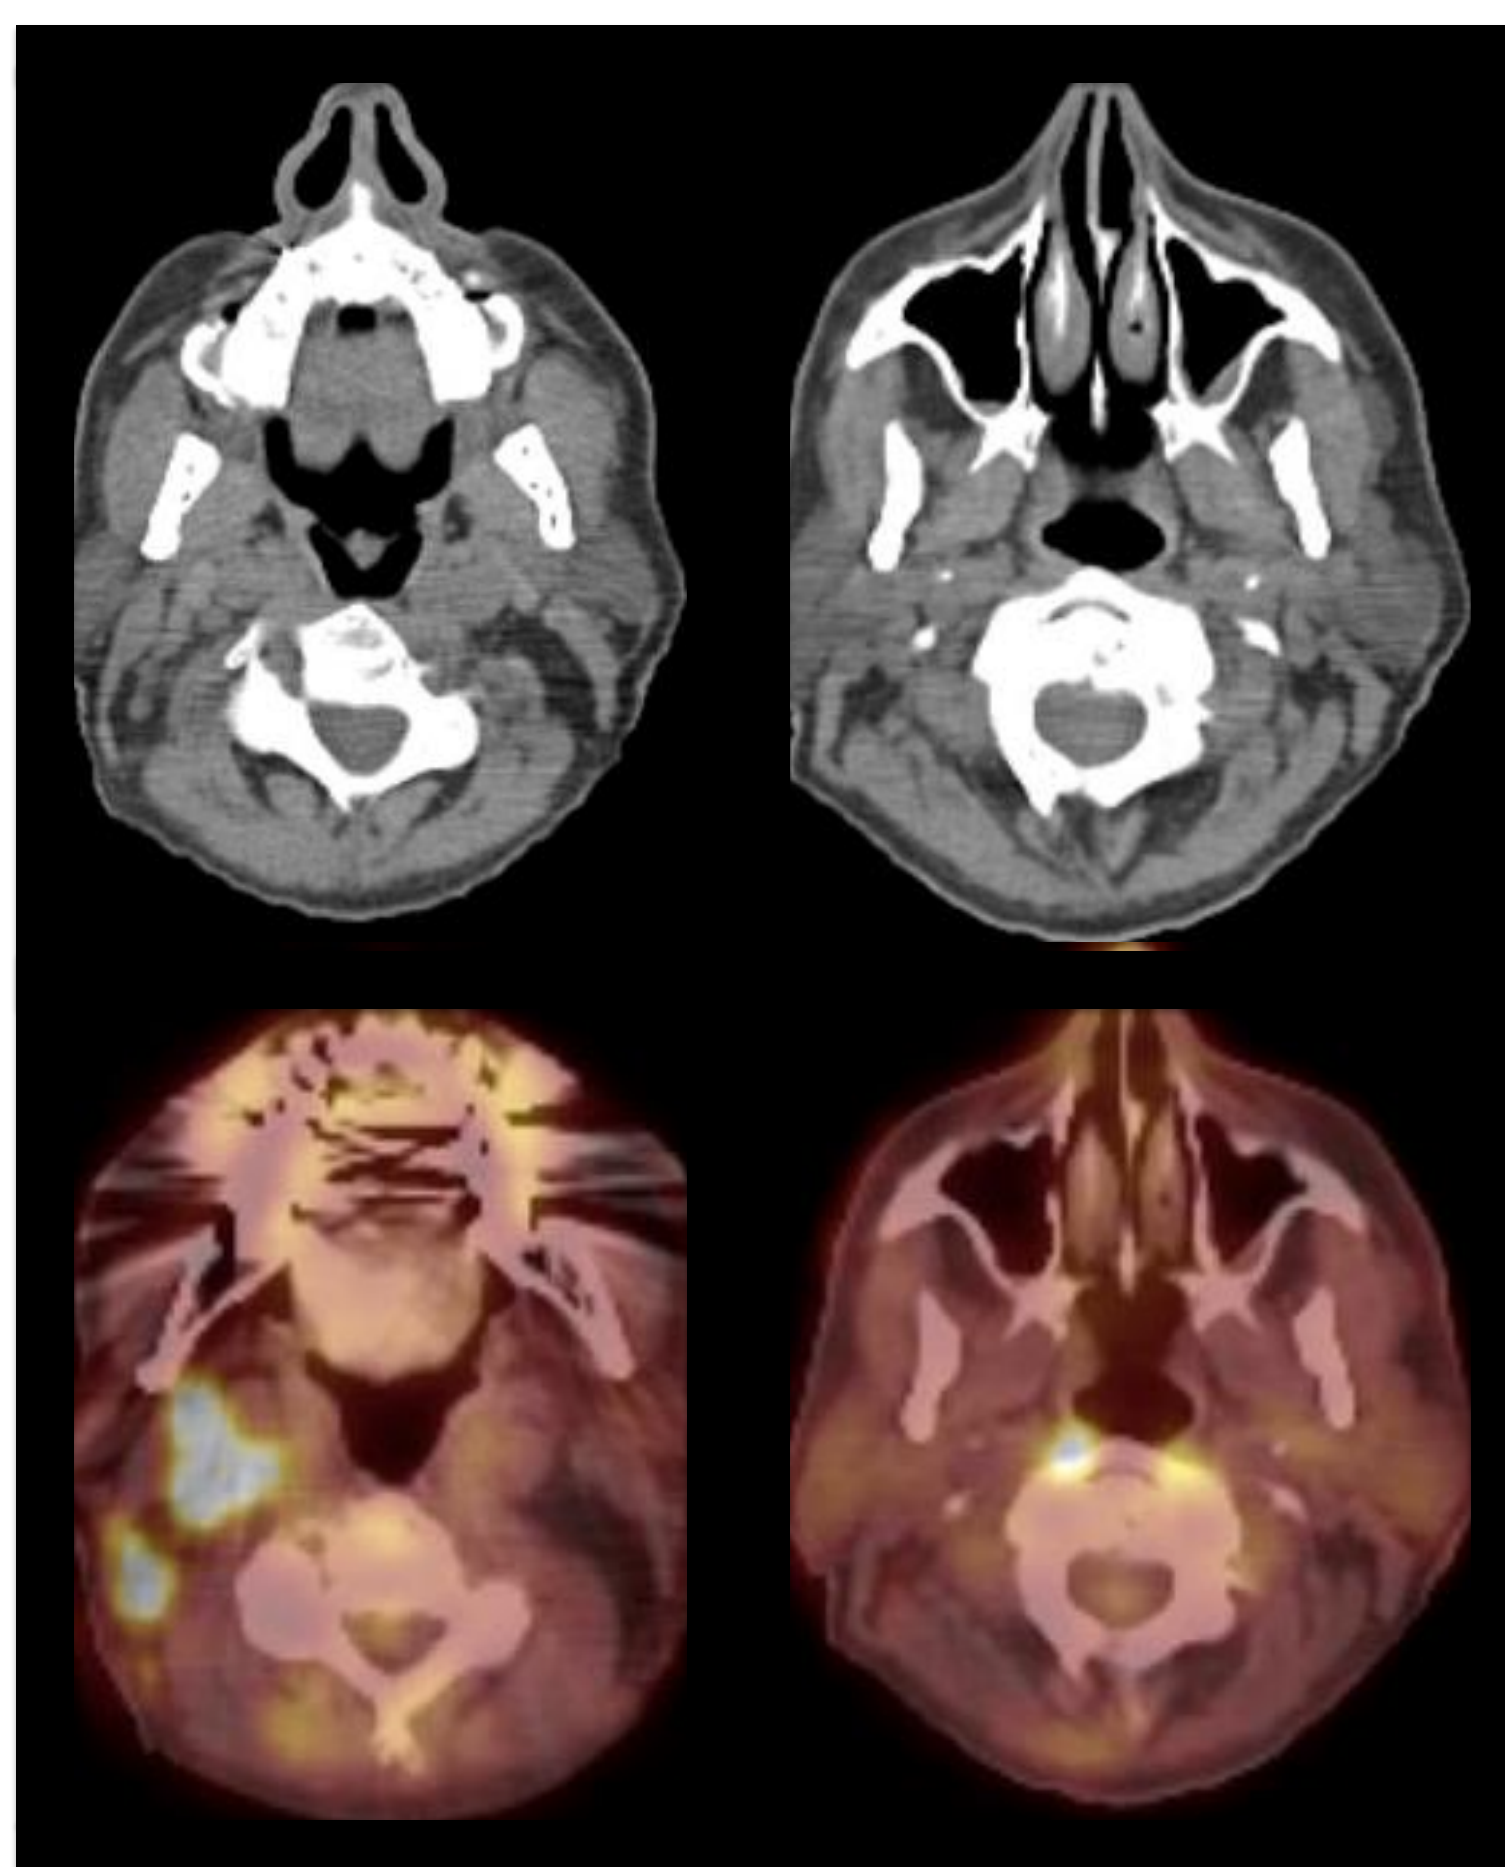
CT scan demonstrating deep parotid space and parapharyngeal space of the current patient described, with corresponding PET CT images below.
